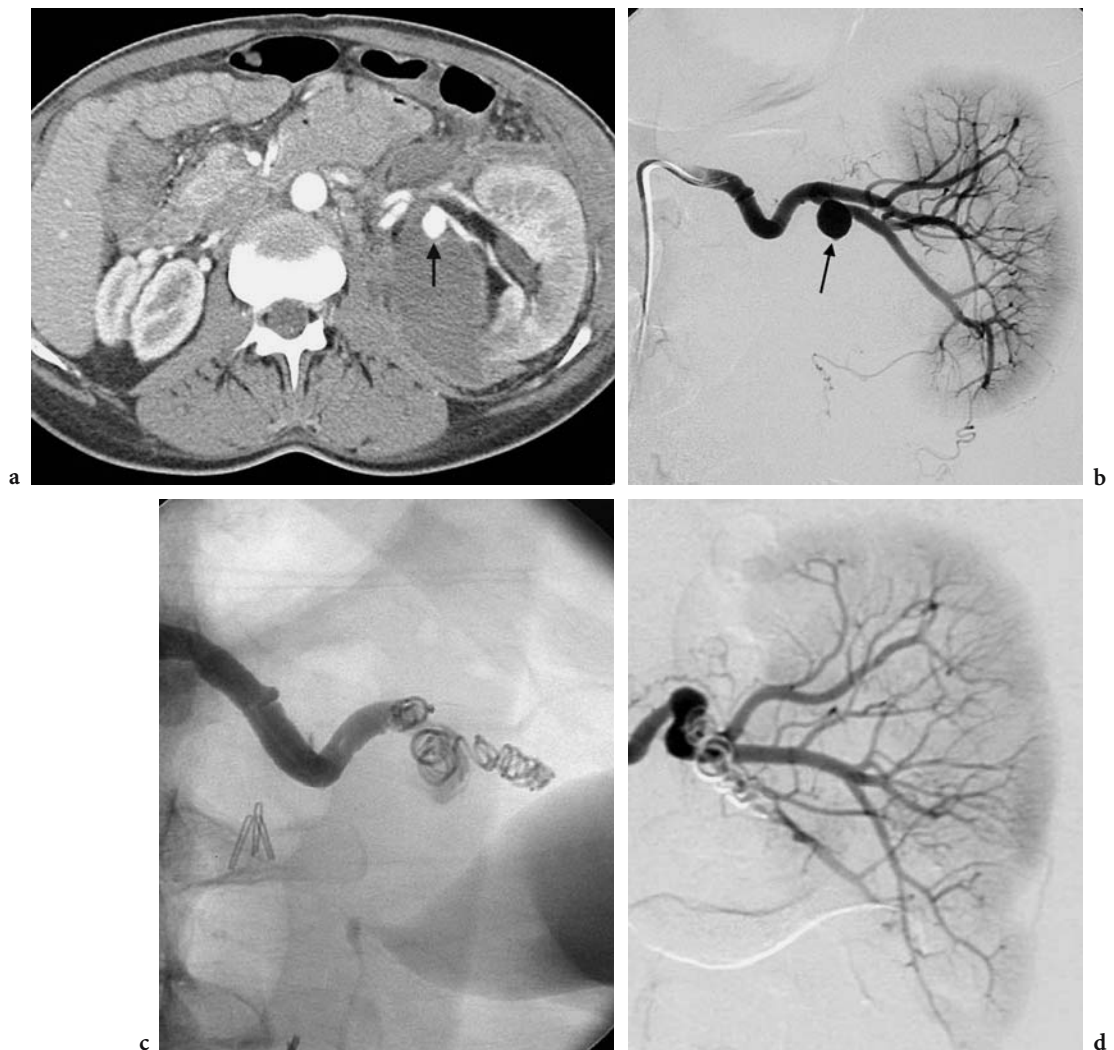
a CT of a 38-year-old female who had flank pain after a partial nephrectomy. A hematoma and a pseudoaneurysm (*arrow*) are seen. b Left renal arteriogram shows a pseudoaneurysm near the origin of the inferior branch of the renal artery. c Coils were placed distal and into the pseudoaneurysm, and an attempt was made to place the final coils just proximal to the pseudoaneurysm. These last coils moved out into the main renal artery occluding all renal artery flow. d An arteriogram done 3 months later shows some recanalization through the displaced coils with some perfusion to the kidney
